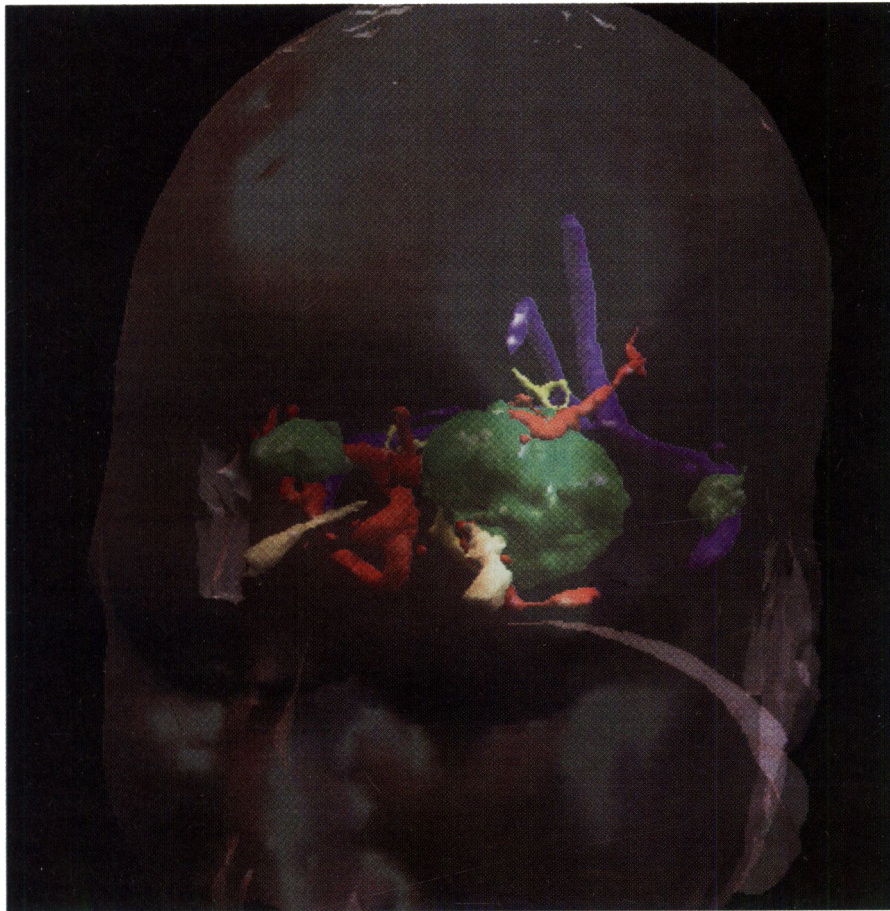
Three-dimensional reconstruction of a meningioma. This is created from MRI scans.
